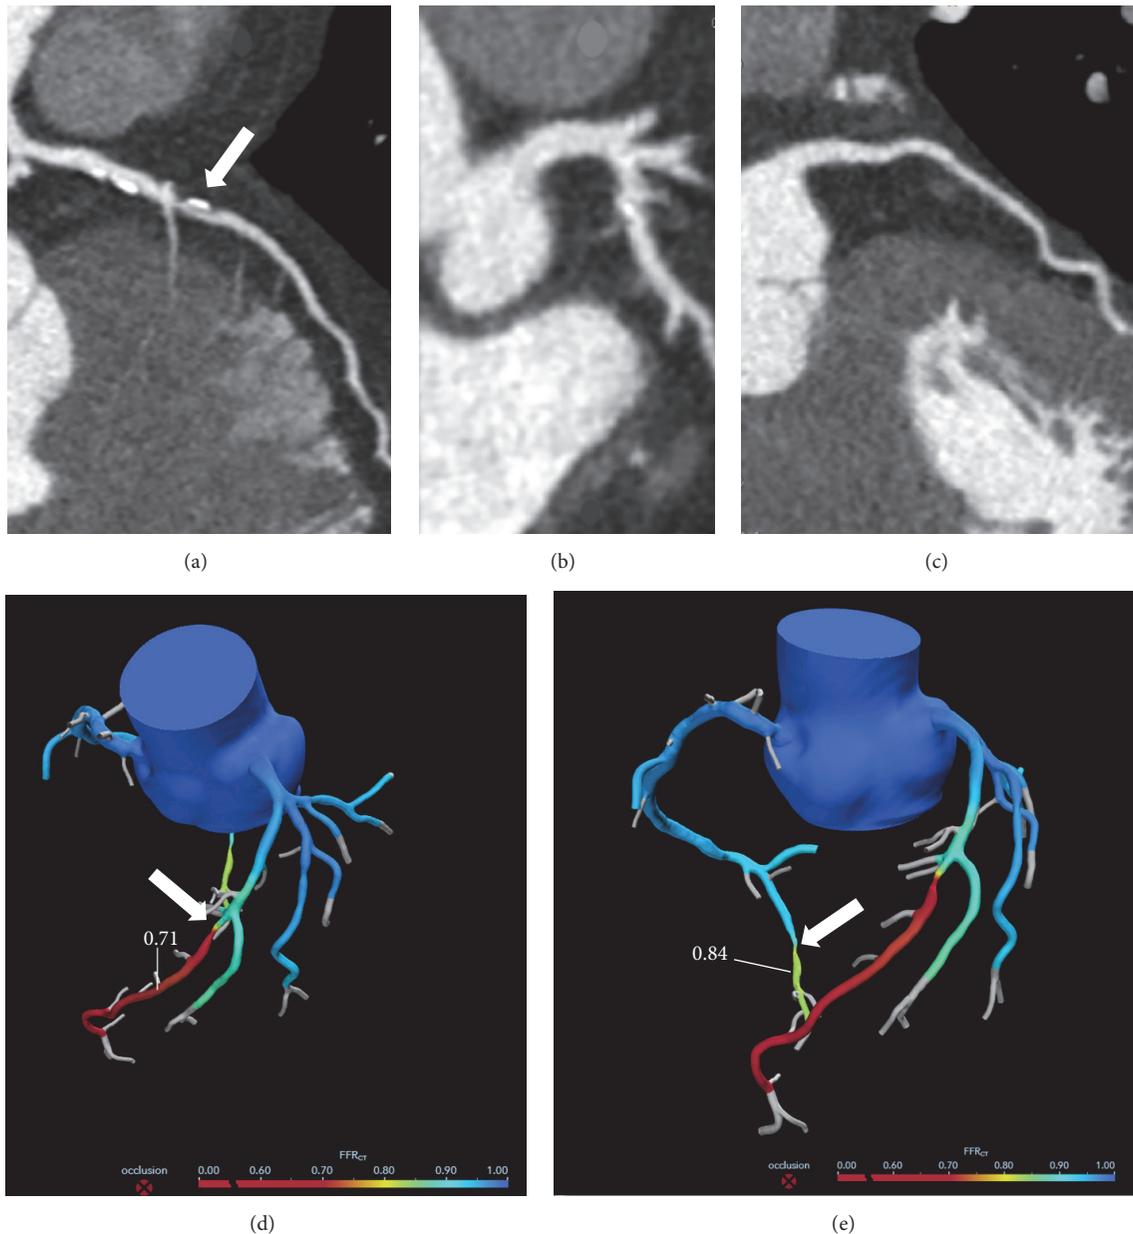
Computed tomography coronary angiography (CTCA) and fractional flow reserve CT (FFR_{CT}). (a) Left anterior descending (LAD) artery. White arrow indicates a mixed, severely obstructive plaque at middle LAD. (b) Right coronary artery (RCA) with a small calcific spot. (c) Left circumflex (LCx) artery does not show atherosclerotic plaques. (d), (e) Graphic representation of FFR_{CT} calculation. (d) Following LAD stenosis (white arrow), the value is 0.71. (e) Following RCA stenosis (white arrow), the value is 0.84.
